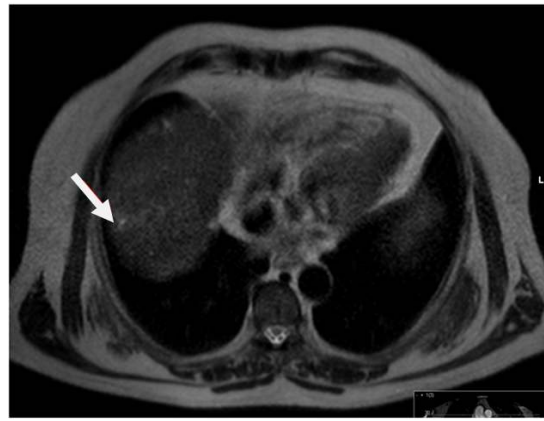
HCC - MRI, axial T2 TSE. Nodular lesion slightly hyperintense compared to the adjacent parenchyma in a patient with chronic liver disease
